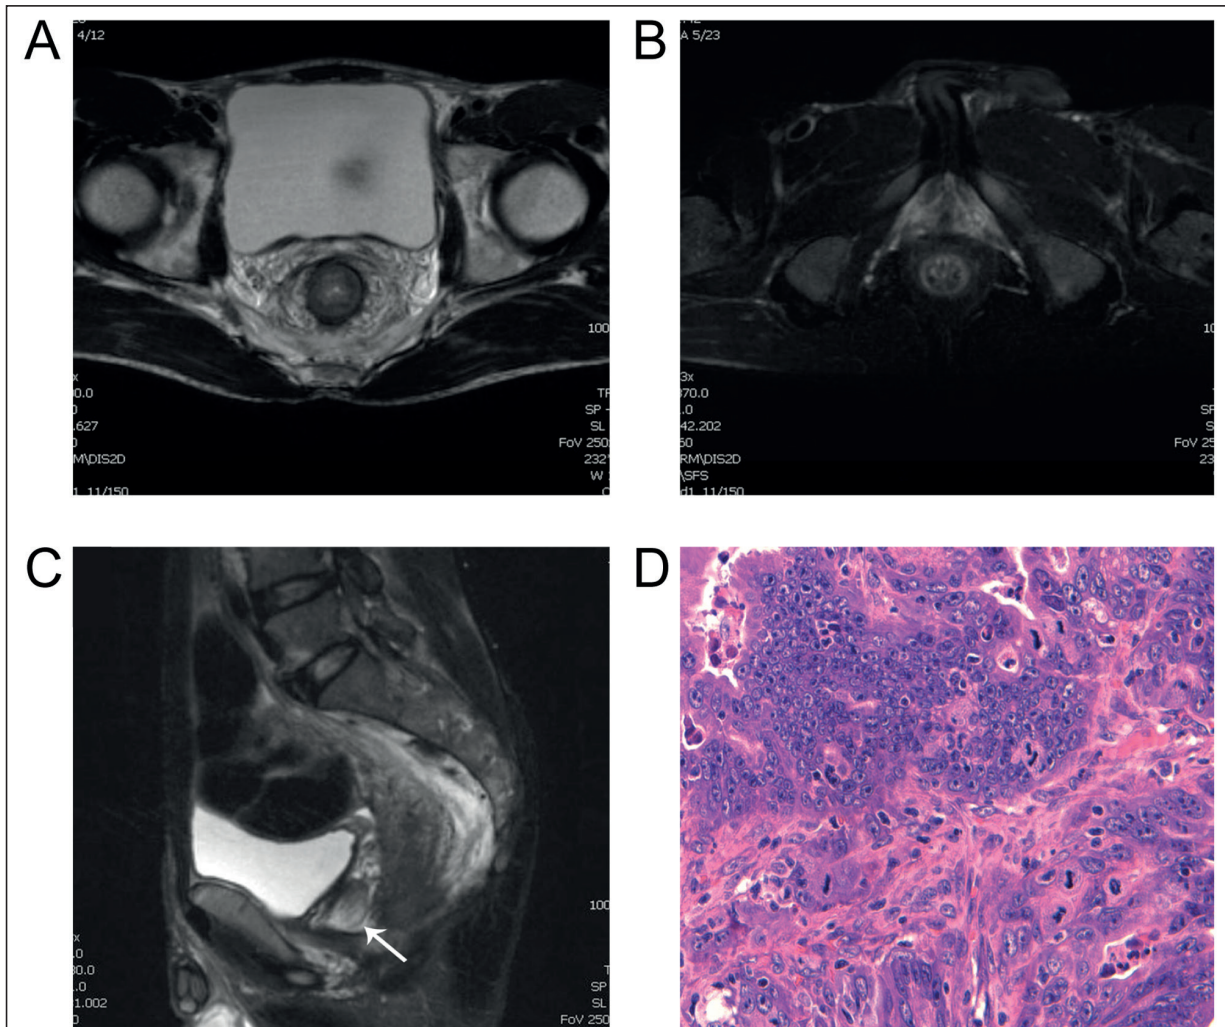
MRI materials of patients with rectal cancer. Male patients aged 51 years old. A-B, T2WI and T1WI images show significant thickening of the rectal wall. T2WI shows that the surrounding of the tube wall exhibits low signal which is considered to be space occupying lesion. C, shows bilateral levator ani muscle (arrow) at the coronal site of MRI. D, indicates poorly differentiated gland cancer through pathological diagnosis.
